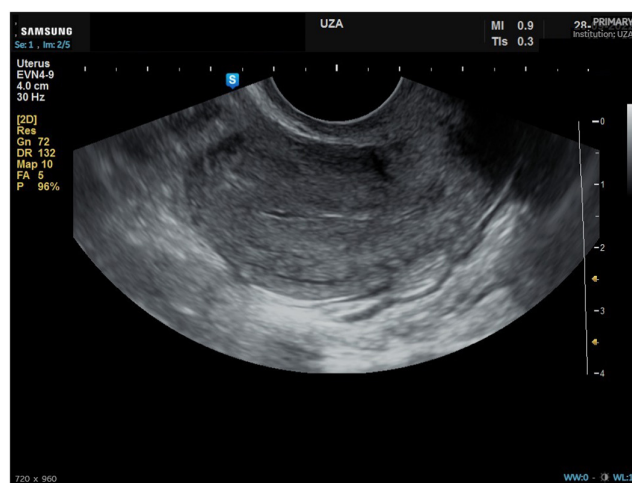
Transvaginal ultrasound at follow-up appointment showing no remnant tissue intrauterine.
